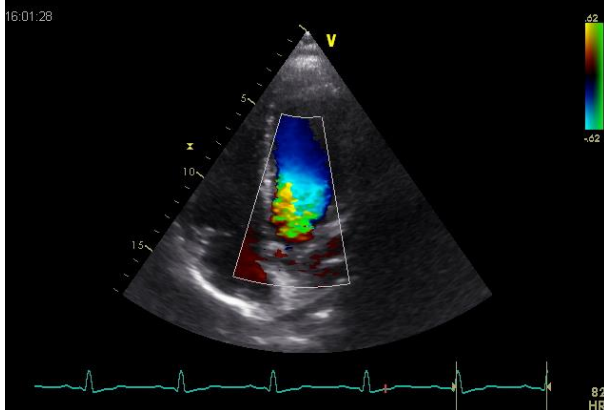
Color Doppler aortic valve
